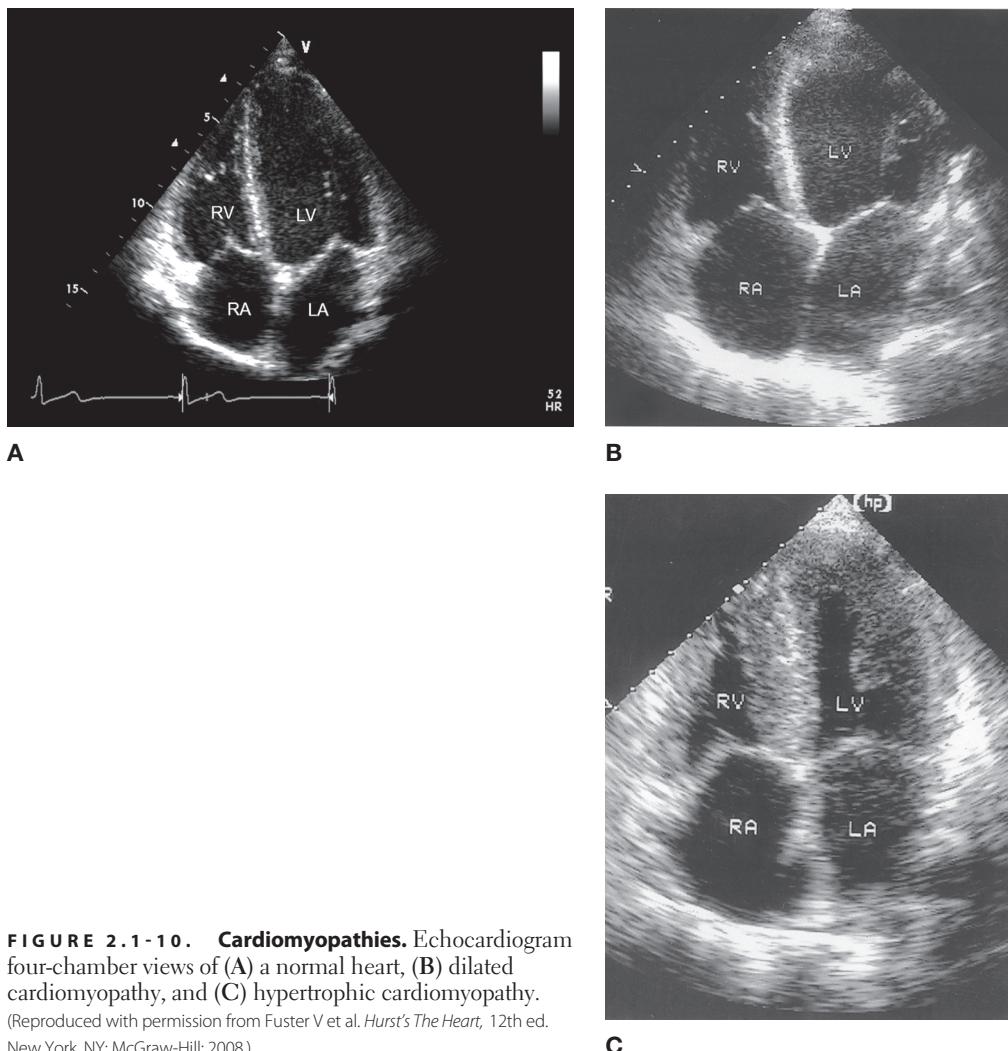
Cardiomyopathies. Echocardiogram four-chamber views of (A) a normal heart, (B) dilated cardiomyopathy, and (C) hypertrophic cardiomyopathy. (Reproduced with permission from Fuster V et al. *Hurst's The Heart*, 12th ed. New York, NY: McGraw-Hill; 2008.)
